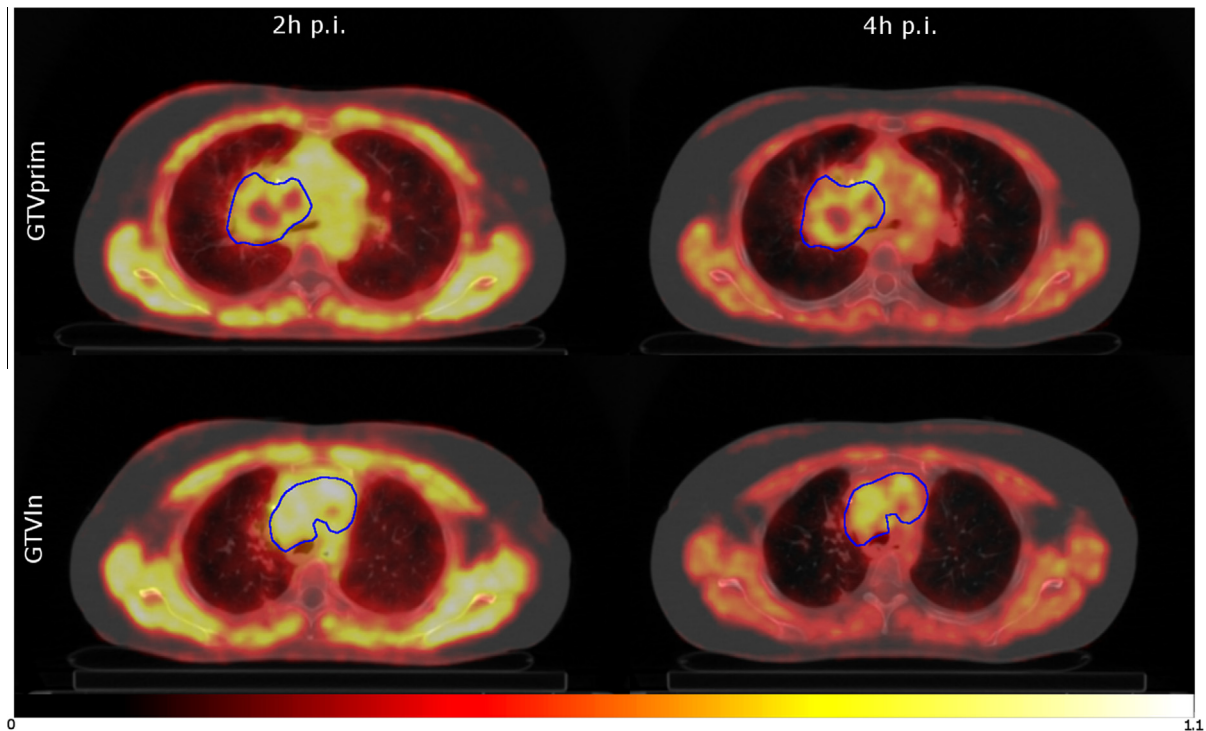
Example of two transversal slices of the [¹⁸F]HX4 CT/PET image of patient 14 at 2 h and 4 h p.i. showing the primary tumor (GTV_{prim}) and involved lymph nodes (GTV_{ln}).
